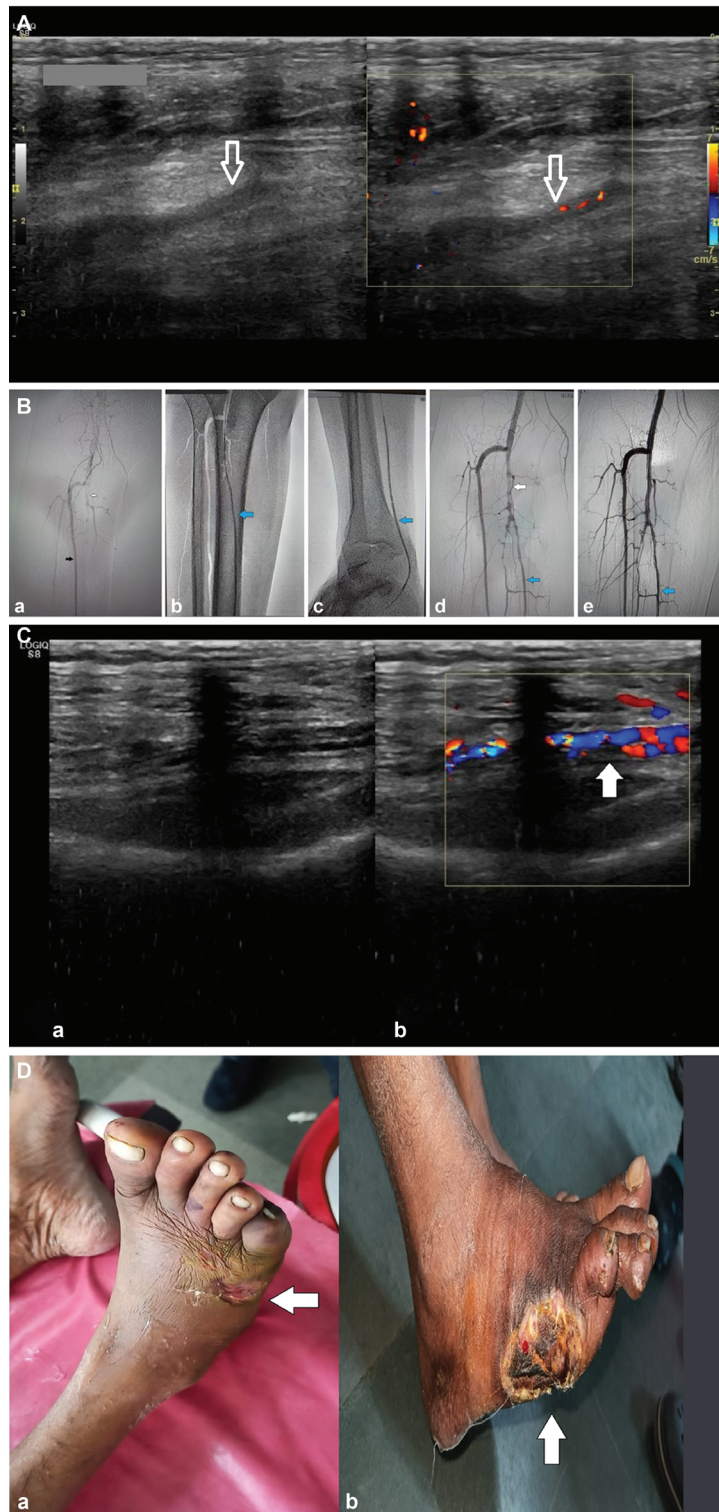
Pretreatment Doppler in the longitudinal section at the middle part of the right leg reveals complete thrombotic occlusion of the right posterior tibial artery (PTA) (white arrow) with no flow detected in the vessel. Fig. 1B Digital subtraction angiography of below the knee arteries demonstrates: a. Faint opacification of tibioperoneal trunk (white arrow) and nonvisualization of PTA and peroneal artery. Anterior tibial artery (ATA; black arrow) shows optimal opacification. b. Balloon angioplasty of proximal PTA (blue arrow). c. Balloon angioplasty of distal PTA (blue arrow). d. Postangioplasty check angiogram revealed irregular short tight strictures of the tibioperoneal trunk (white arrow), optimal opacification PTA (blue arrow), and peroneal artery. Balloon mounted bare-metal stent was deployed in the tibioperoneal trunk to tackle the short segment strictures. e. Post-drug-eluting balloon and poststent angiogram showing good opacification of tibioperoneal trunk, PTA (blue arrow), and peroneal artery. Fig. 1C Follow-up Doppler at 6 months, gray scale (a) and color Doppler images (b) in longitudinal section reveal restoration of blood flow in right distal PTA (white arrow) with peak systolic velocity of 22 cm/s and residual stenosis less than 50%. Fig. 1D Pre- (a) and (b) postangioplasty clinical pictures of the right foot of the patient: a) Ulceration with gangrenous changes and edema seen on the lateral aspect of the right foot and fifth toe (white arrow). b) The lateral part of the right foot with the gangrenous right fifth toe was amputated; the ulcer healed well with resolution of the edema and discoloration of the rest of the foot with clinical improvement in Rutherford class (white arrow).
